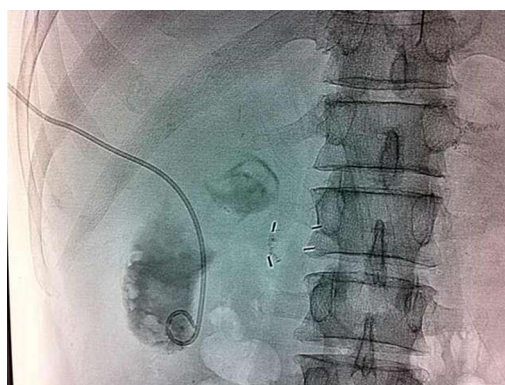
Ultrasound guided percutaneous transhepatic gallbladder drainage in case 3.
